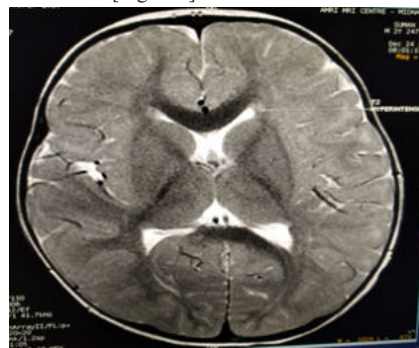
Magnetic Resonance Imaging. Hyper intensity in the head of the left caudate nucleus in T2 weighted image.
